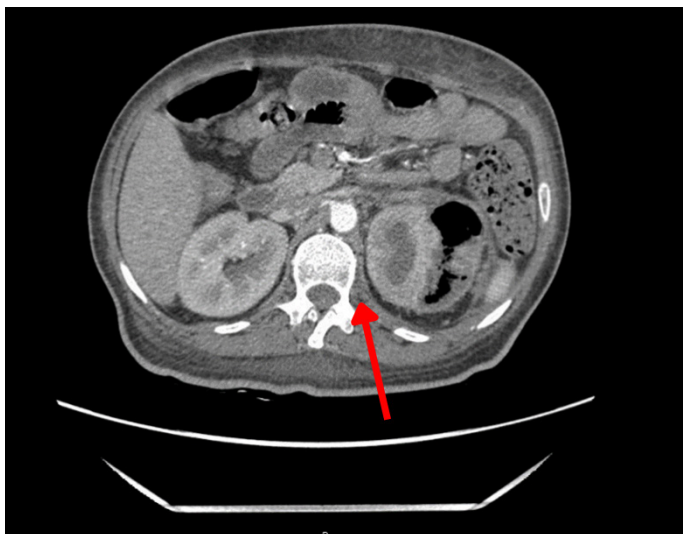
Class 3B EPN. Computed tomographic scan shows left-sided EPN with extension of gas to the pararenal space at the coronal plane (arrowhead)
